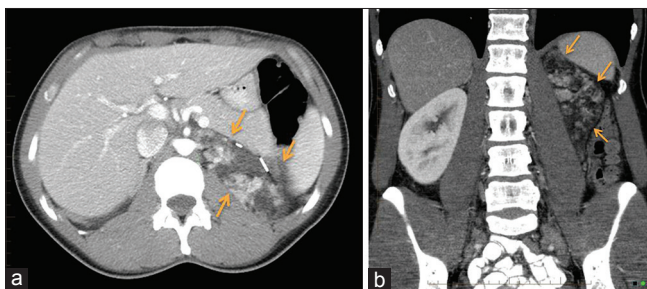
Computed tomography abdomen in 2014 in axial section (a) and coronal reformation (b) showed new heterogeneous, predominantly fat-containing, enhancing lesion measuring 9.1 cm × 3.5 cm at the left renal surgical bed (arrows), with features suggesting angiomyolipoma
